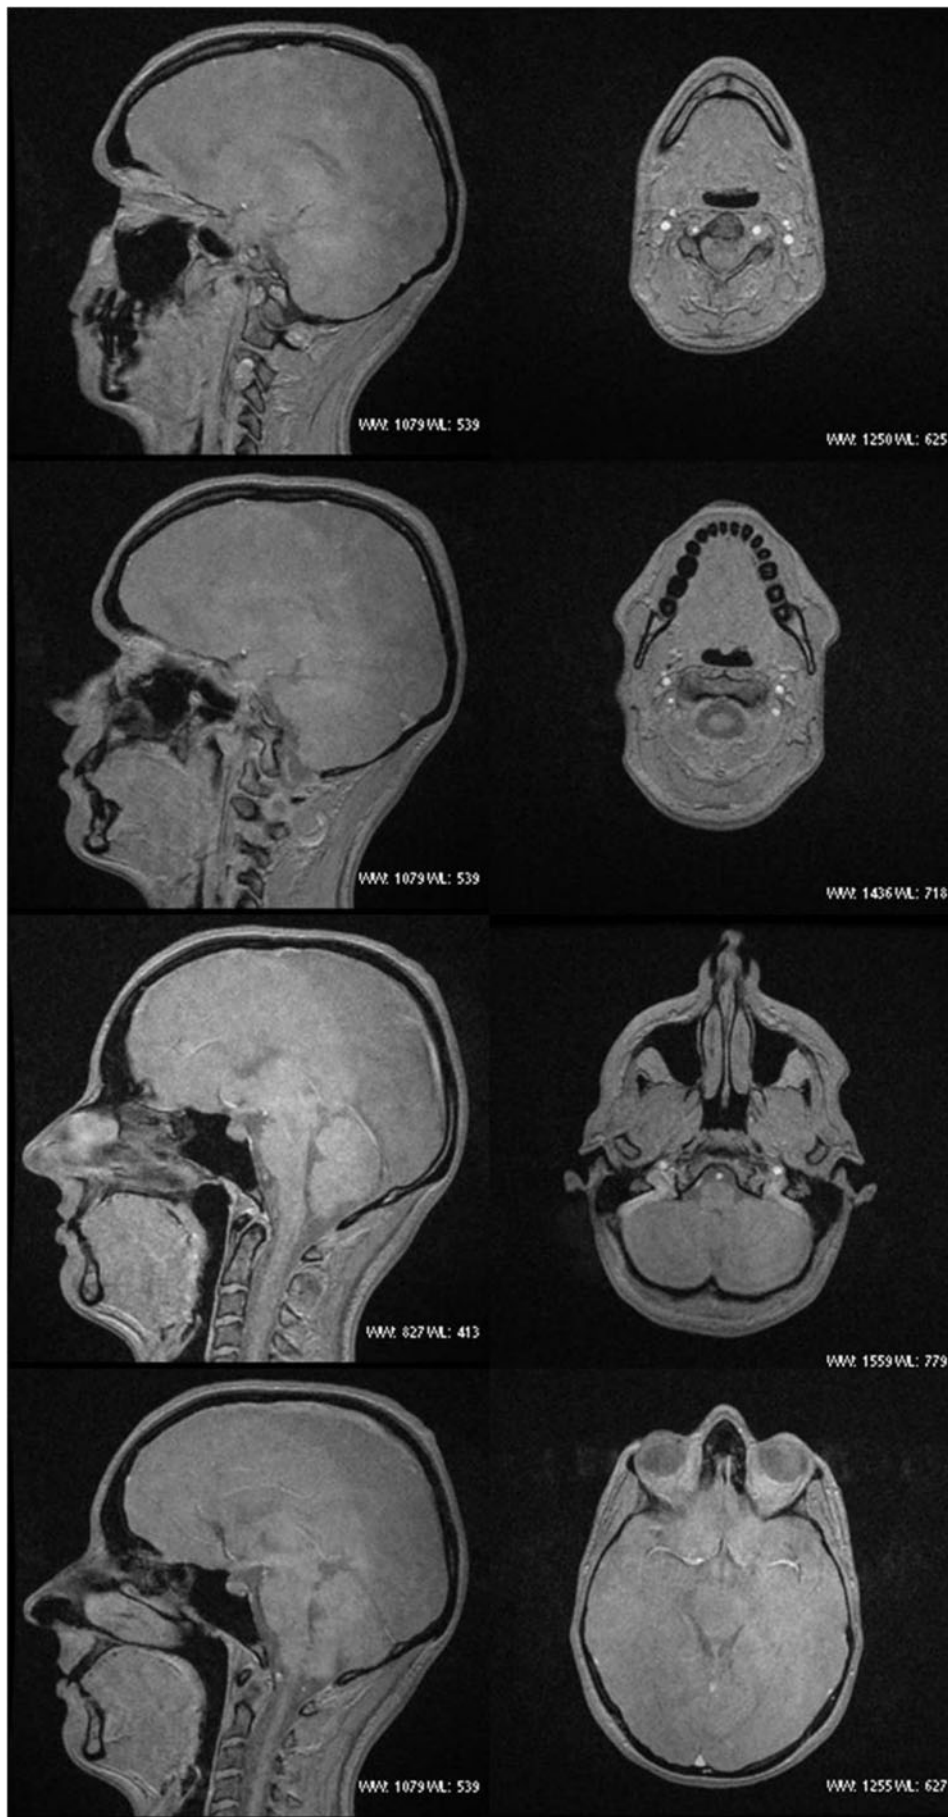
Black bone MRI sagittal and axial images.
